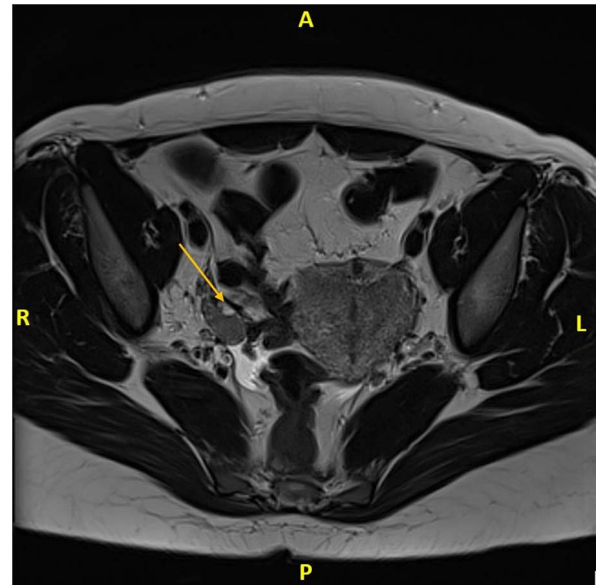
MRI demonstrating a solid mass on the right ovary (arrow) measured to 15x10 mm in size. An MRI performed 2 months prior did not identify the mass and was without abnormal findings. The uterus and left ovary were normal on the MRI. No suspicious findings in lymph nodes or the peritoneal cavity. *Abbreviations:* MRI; magnetic resonance imaging 120x120mm (300x300 DPI)
